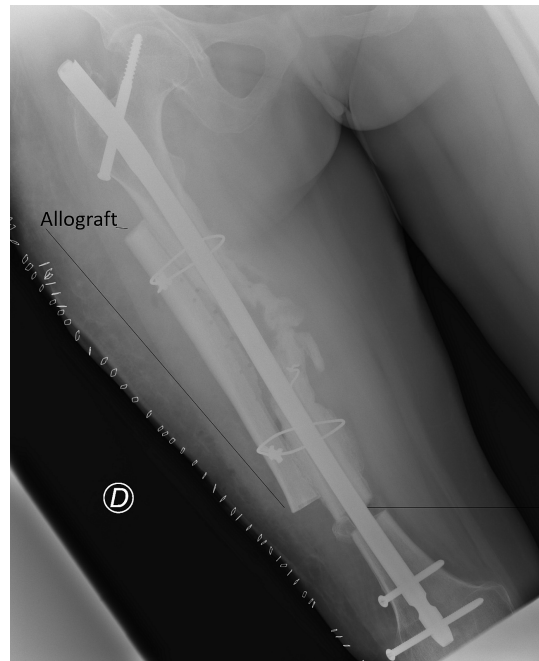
(a) Case no. 2. CT scan depicting the broken cortical graft and posterior located femur plate. (b) Case no. 2 Radiograph after the broken plate removal and posterior strut allograft placement. Two crossing 7.3 mm crossing screws were used to stabilise the knee joint.
